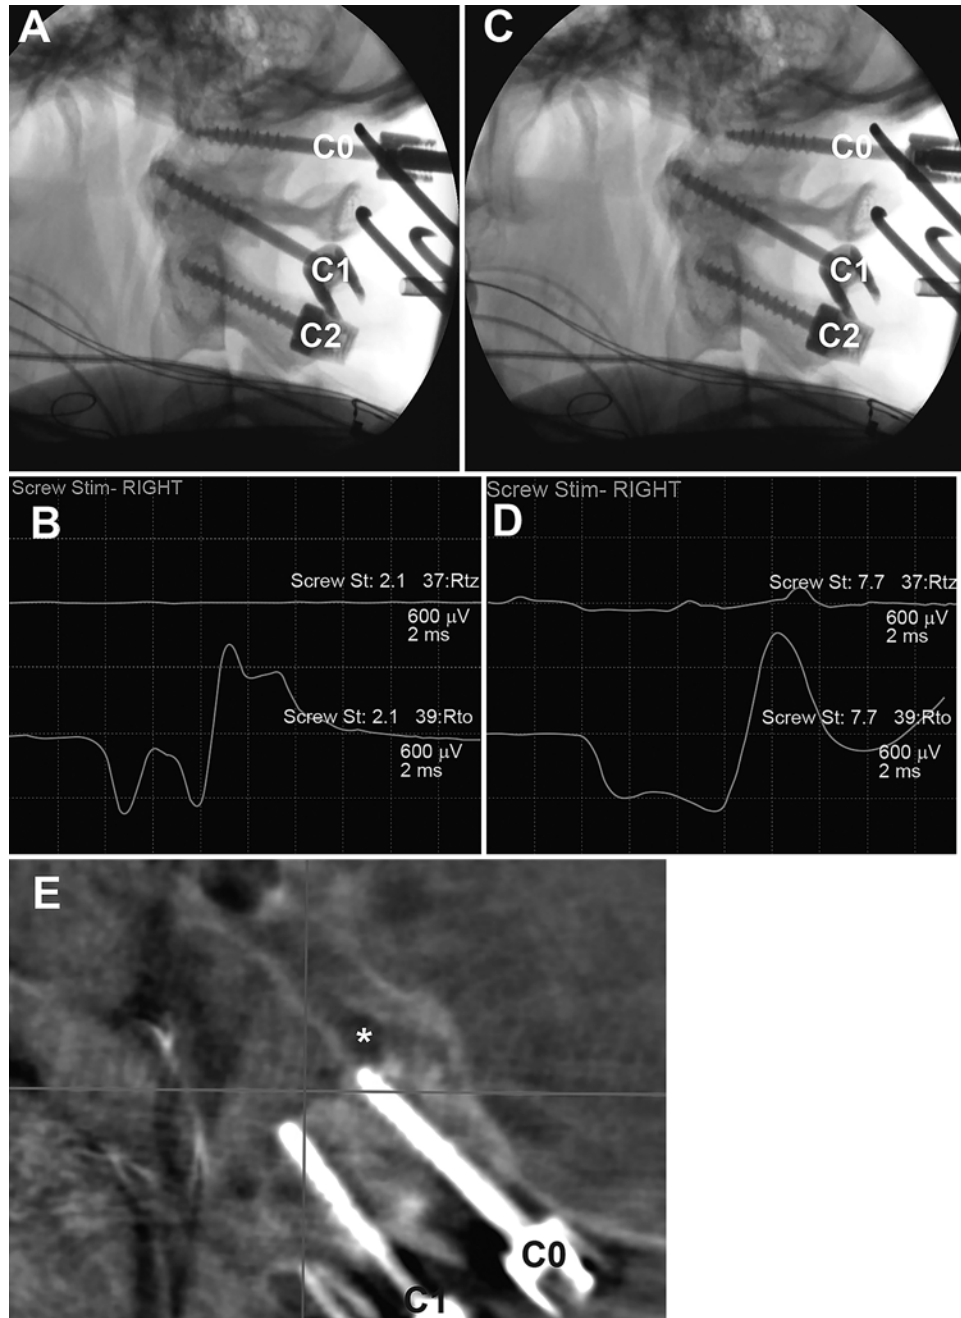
Intraoperative fluoroscopy of condylar screws during the placement. A: Fluoroscopy demonstrating the initial position of a condylar screw corresponding with a low-threshold stimulation (2.1 mA; B). C: Fluoroscopy showing modified screw placement, resulting in a stimulation threshold higher than the MAT of 7.7 mA of EMG activity (D). E: The curved parasagittal intraoperative CT scan showing that the former screw trajectory was tangential to the inferior wall of the hypoglossal canal. In this case the monitoring was uneventful during the hand drilling, but the screw probably caused an expansion of the condylar bone toward the canal, which was detected by the screw stimulation. Rto = right tongue; Rtz = right trapezius; Screw St = condylar screw stimulation value in mA. Asterisk designates hypoglossal canal. C0 = condylar screw; C1 = lateral mass C1 screw.
